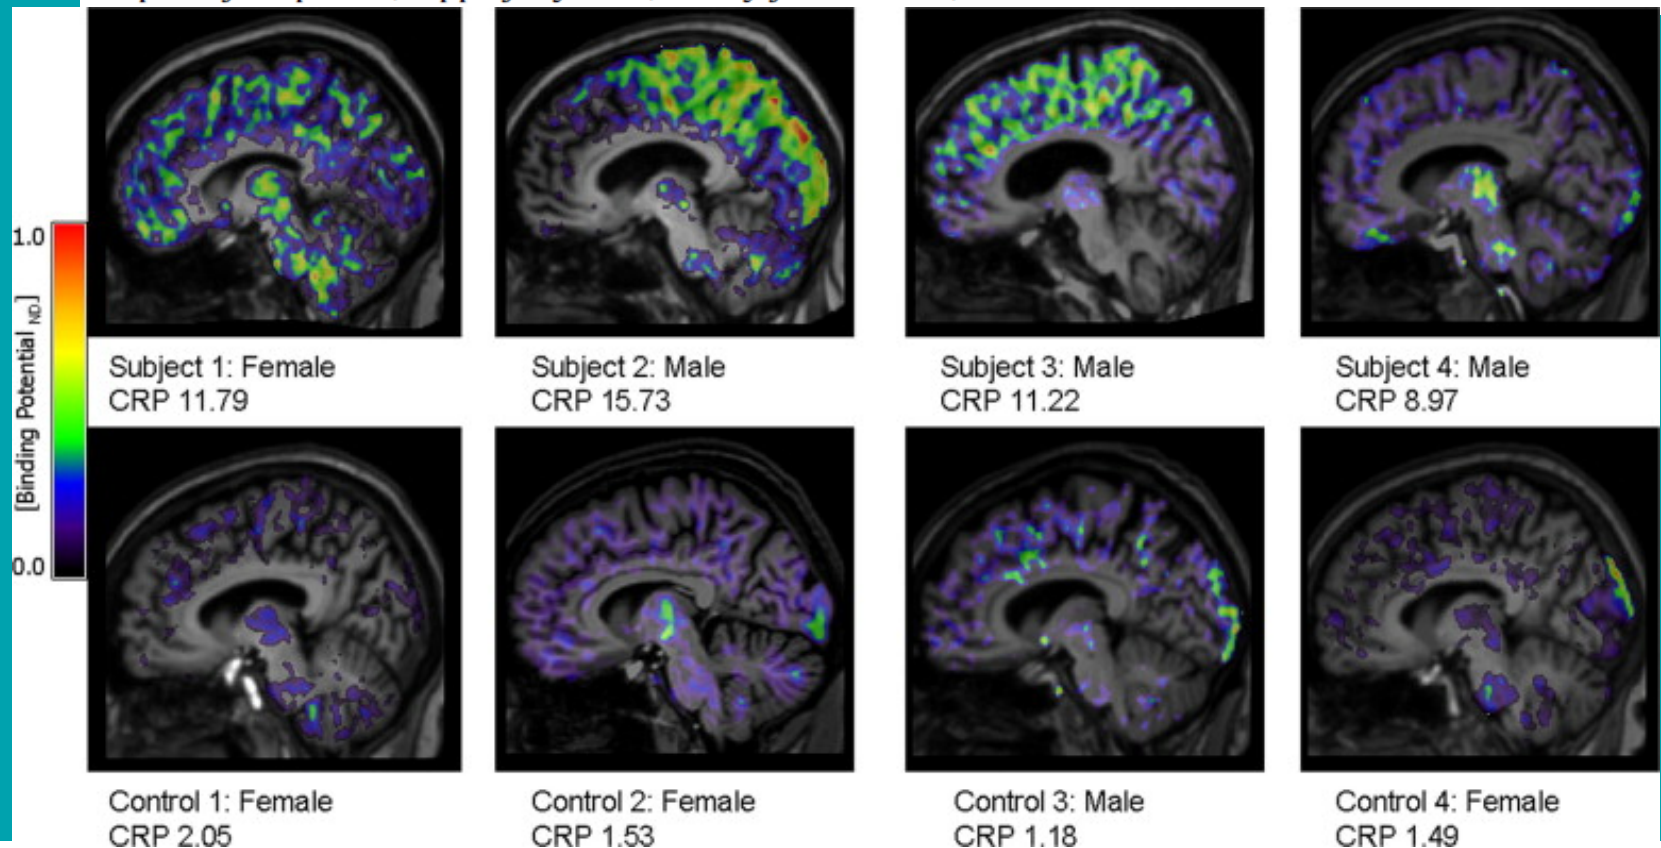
[¹¹C](R)-PK11195 binding potential (BP_{ND}) images are shown for all subjects and control participants. Images are displayed on each subject's respective T1 MRI scan normalised to the SPM5 T1 brain template. The value for each individual's CRP at the time of PET scanning is also shown.
